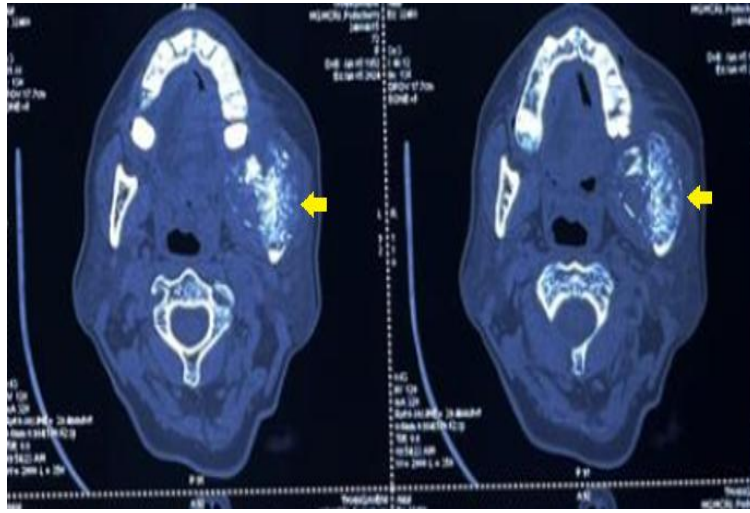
CT Contrast – Axial sections reveal a hyperdense diffuse lesion in the left angle of mandible region (indicated by yellow arrows)
